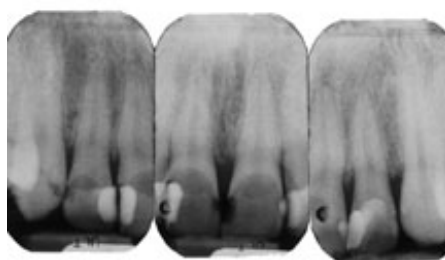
Periapical radiographs of the maxillary anterior dentition reveal that the lengths of the anatomic crowns are 2 to 3 mm longer than the lengths of the clinical crowns. Note the presence of unexposed enamel located 2 to 3 mm apical to the carious lesions.
